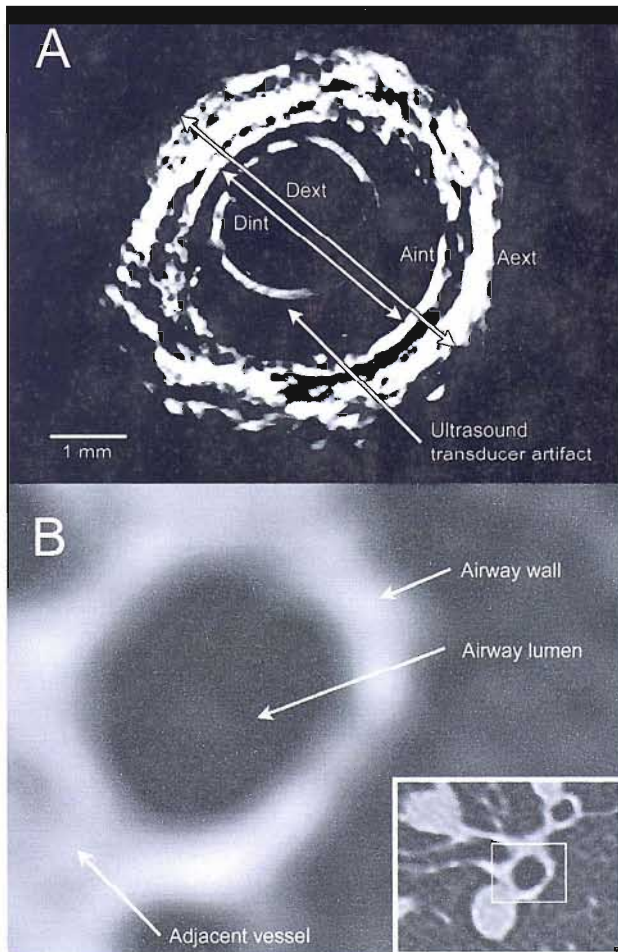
Comparison between EBUS and HRCT images of the same airway.
